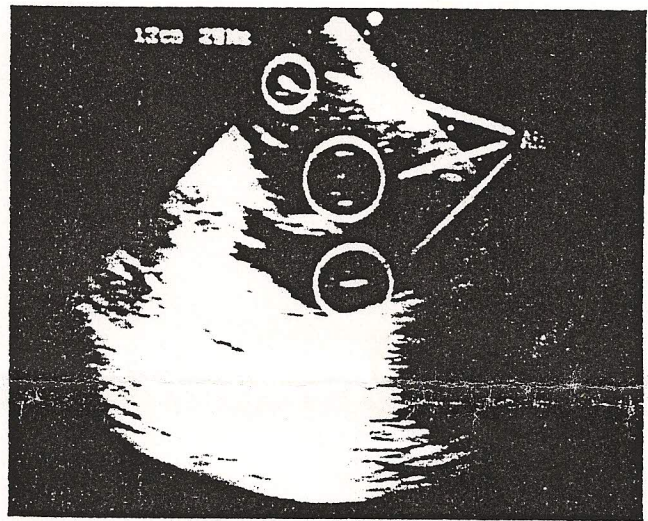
Transoesophageal echocardiographic image demonstrating air bubbles. This amount of air is classified as grade 3.
